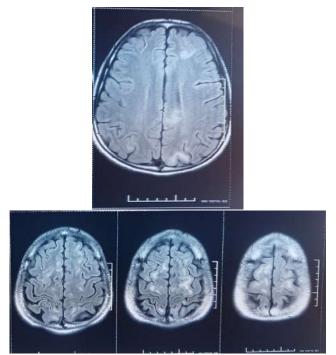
MRI of brain suggestive of leukoencephalopathy in both cerebral hemisphere.
